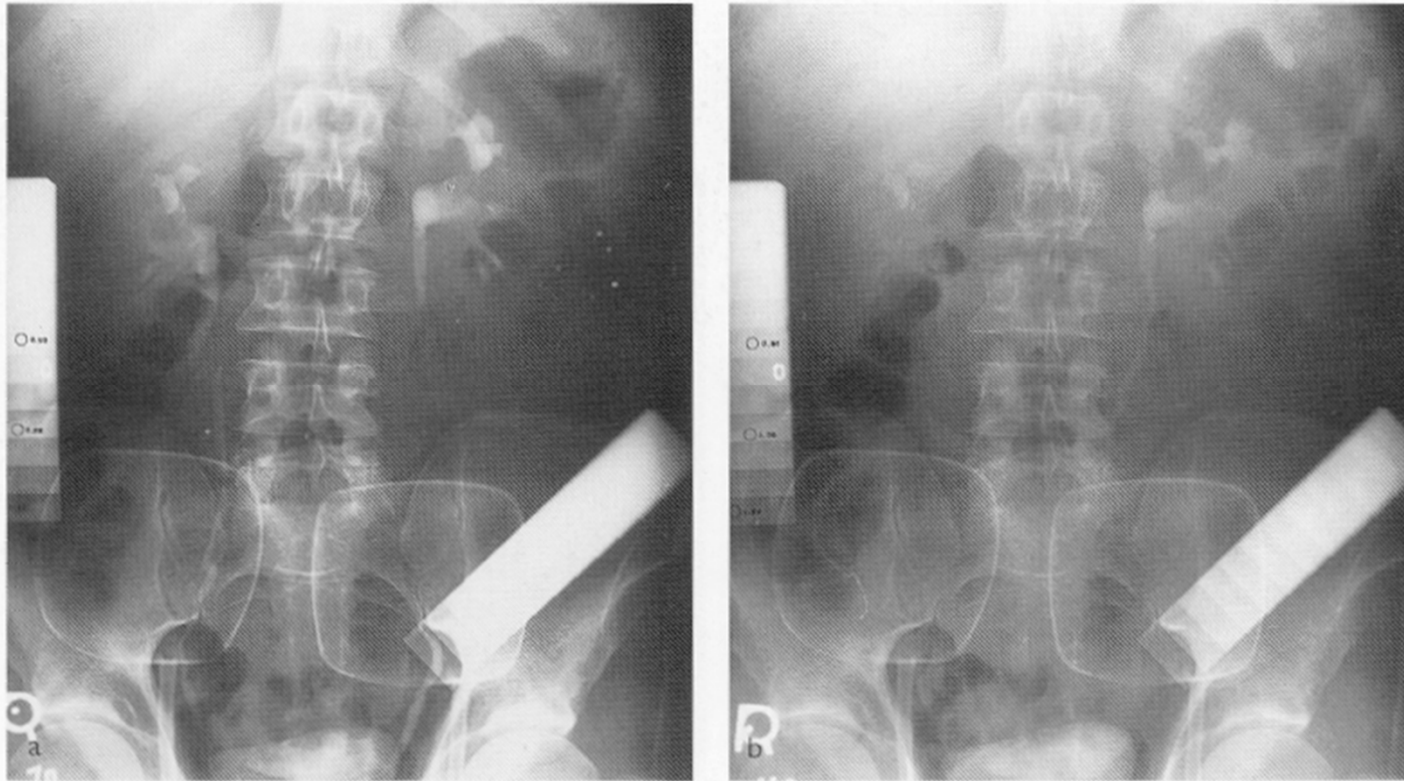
An important, and adjustable, determinant of image quality in radiography is the voltage applied across the X-ray tube by the generator. The image to the left, (a), was made at a lower voltage (70,000 V) than (b), the one on the right (110,000V). As a result, (a) more clearly shows the two ureters, which are carrying urine (and iodine-based contrast agent) from the kidneys to the bladder. The lower the voltage, the better the contrast, but the greater the amount of radiation dose that is delivered to the patient—one of many trade-offs to be considered in imaging. Courtesy of the American College of Radiology.
